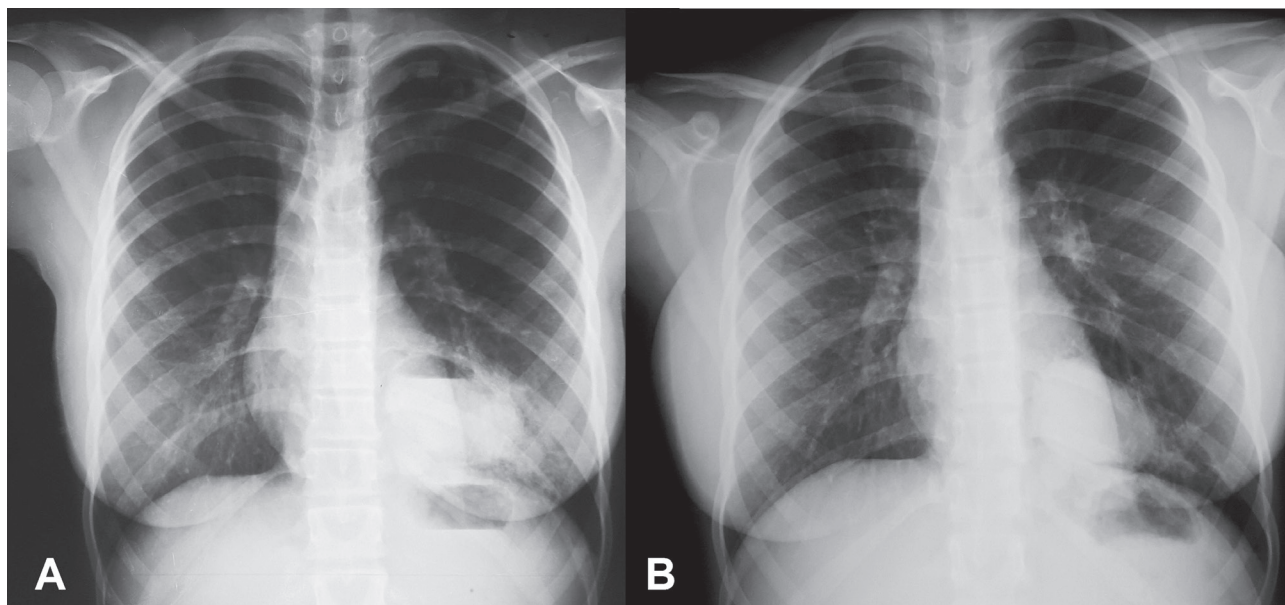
Chest X-ray shows pulmonary consolidation in the left lower lobe with an air-fluid level.
